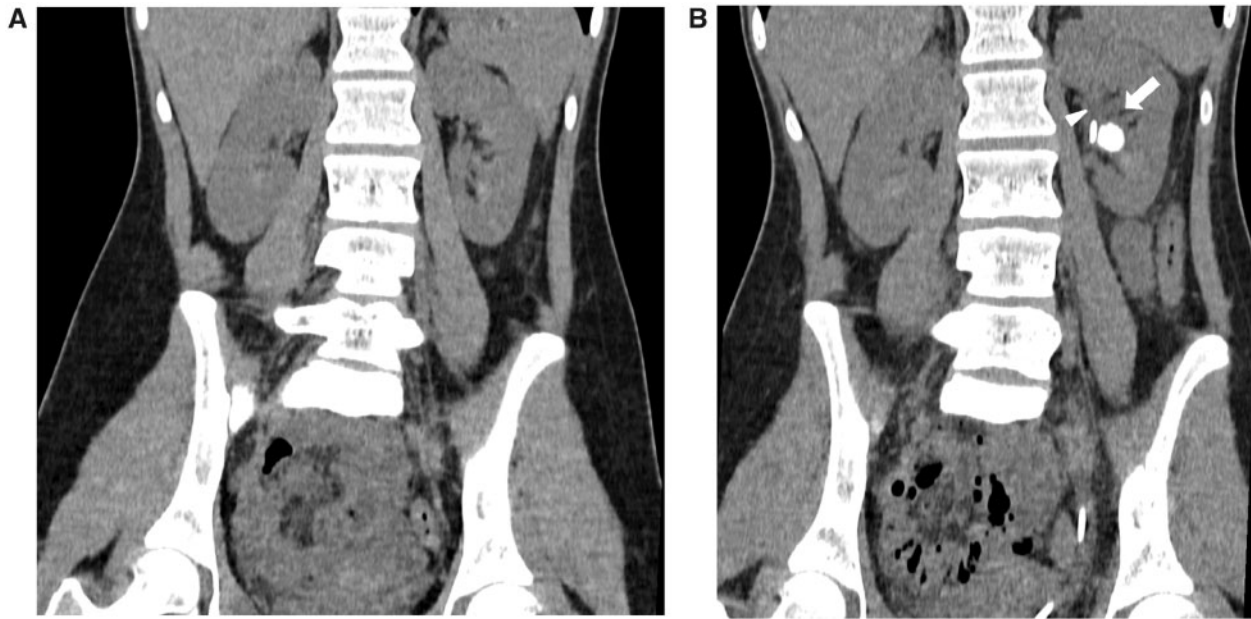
(A) Stone-free low-dose unenhanced CT—September 2019 (120 KVp, 40 mAs, DLP 141.7 mGy\*cm), multiplanar coronal reconstruction. (B) Follow-up low-dose unenhanced CT—February 2020 (120 KVp, 40 mAs, DLP 146.3 mGy\*cm) shows a 15-mm left kidney stone (arrow) next to the double-J stent (arrowhead).
